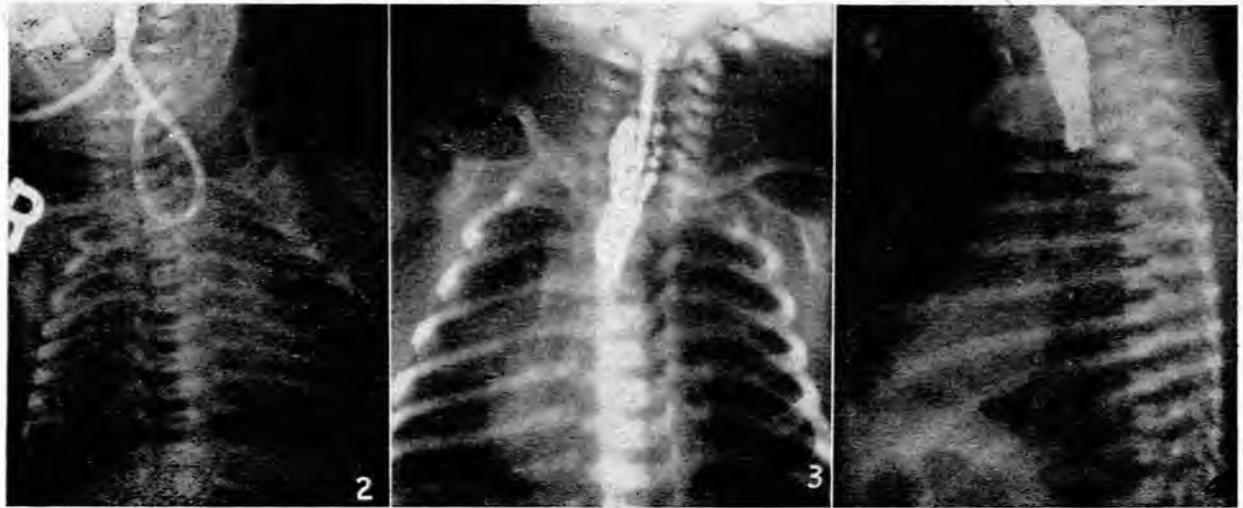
Radiograph demonstrating coiling of catheter in upper blind pouch.
